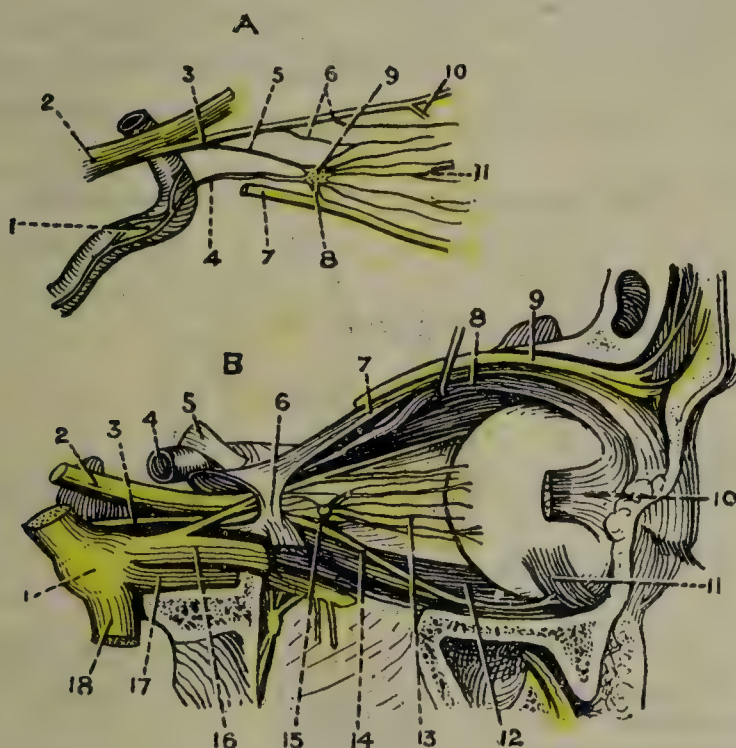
A, THE CILIARY GANGLION; B, THE NERVES OF THE ORBIT (LATERAL ASPECT) (HIRSCHFELD AND LEVEILLÉ).
